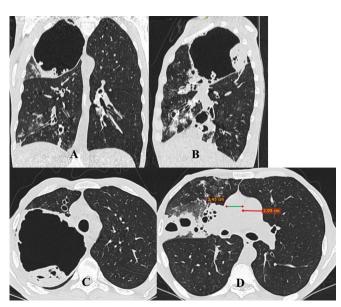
Chest HRCT images of patient 10
